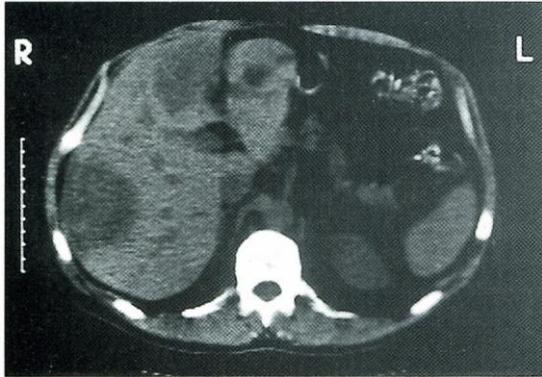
CT is of major value in the assessment of patients with many disorders of the liver and pancreas. This patient has multiple secondary tumour deposits of various sizes throughout the liver, which have contributed to marked hepatomegaly. The primary tumour was in the breast.
